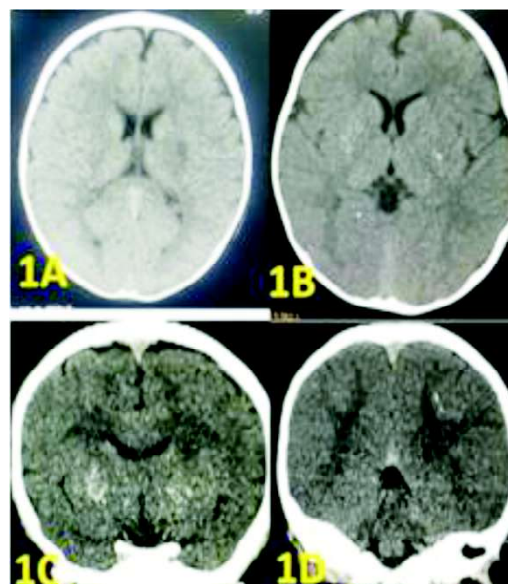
(1A) & (1B) Axial CT brain – hypodense area in left lentiform nucleus suggestive of infarct & punctate hyperdensity in bilateral basal ganglia region. (1C) & (1D) coronal reconstruction CT showing linear area of hyperdensities probably related to mineralization of lenticulostriate arteries
